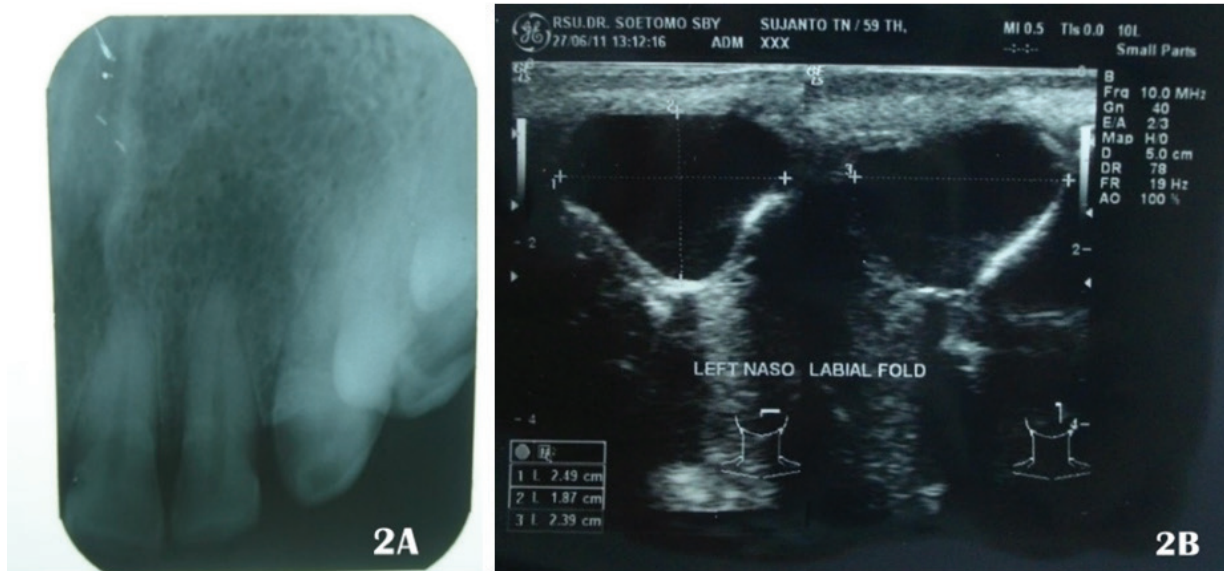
Periapical radiograph showed normal appearance in nasolabial cyst (2A). Ultrasonogram showed cystic lesion in the left nasolabial fold (2B).
